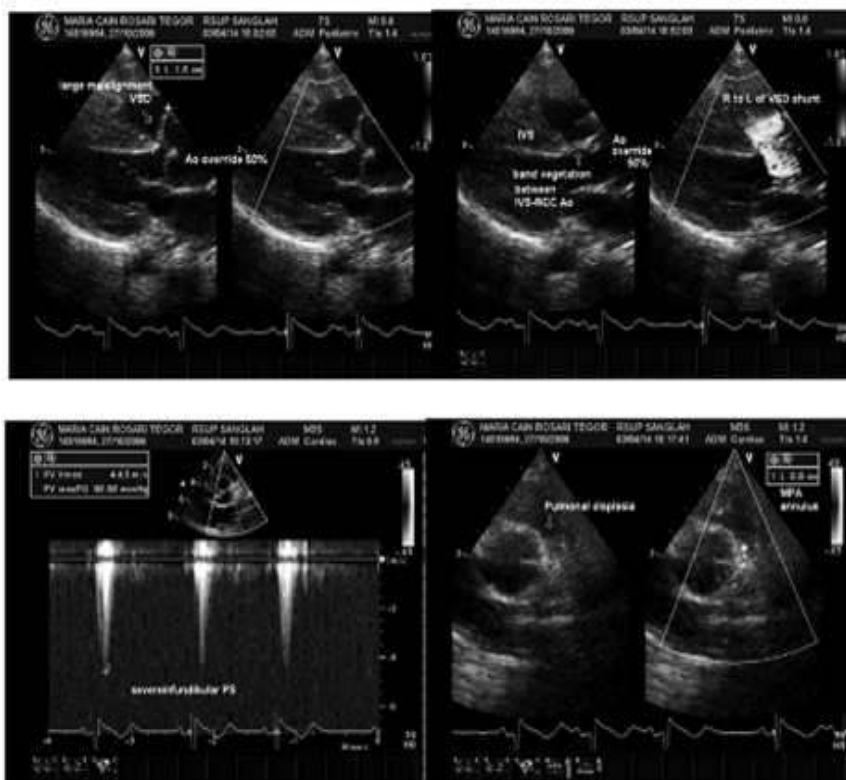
The echocardiography results of the patient.
